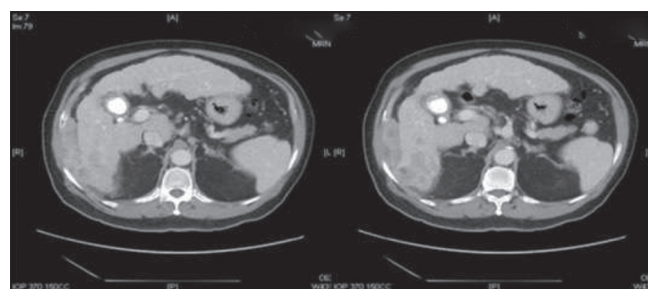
Computed tomography scan in portovenous phase showing a segment VI mass with contrast washout
